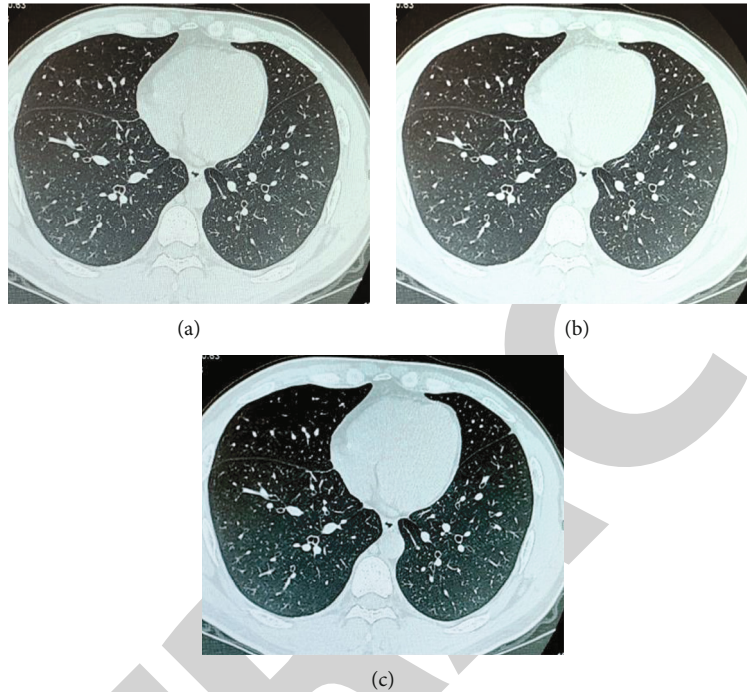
Enhanced processing results of the images by two different algorithms. (a) Represents the original image. (b) Represents the processing results using multihistogram equalization enhancement algorithm. (c) Represents the HRCT image enhancement algorithm in this study.
